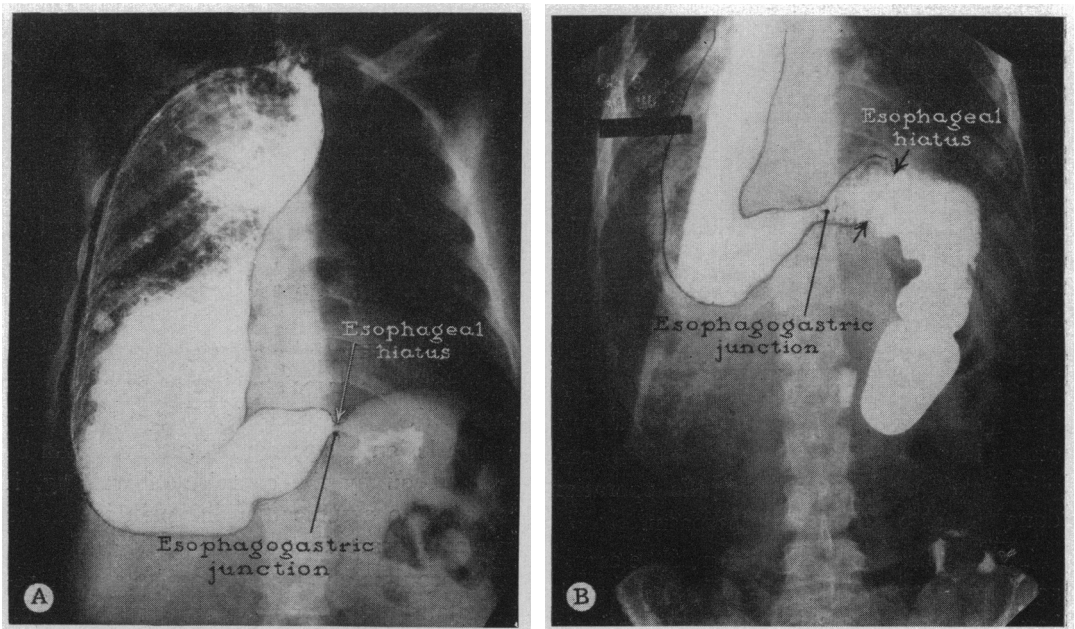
The patient was a 45-year-old woman who had marked cardiospasm which could not be successfully treated by dilatation. In October, 1948, she underwent esophagogastrostomy. Ulceration developed at the esophagogastric junction, and the patient eventually suffered a fatal hemorrhage. *A*, preoperative roentgenogram; *B*, postoperative roentgenogram. (Retouched.)
